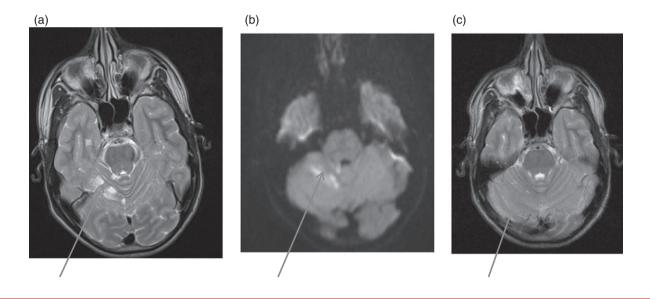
Stroke mimic/probable inflammation. Fifteen-year-old male presented with headache and dysarthria. A diagnosis of right cerebellar infarction was made based on the imaging findings of T2 hyperintense lesions (a) with restricted diffusion (b). No evidence of vasculopathy or a cardiac source for embolism was found despite extensive investigations including formal digital subtraction angiography and transoesophageal echocardiography. Follow-up imaging (c) showed almost complete resolution of initial changes with minimal residual volume loss. This sequence of events would be in keeping with inflammatory changes.
